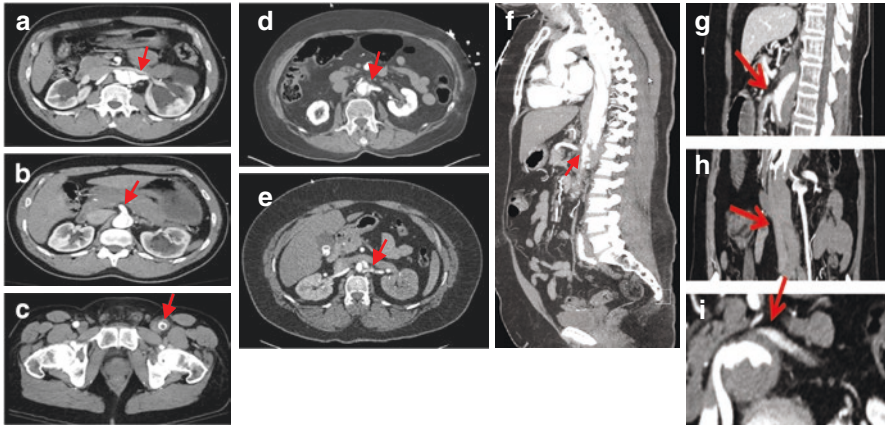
Representative computed tomography images demonstrating malperfusion in type A aortic dissection patients. First panel top (a) Axial view with right renal artery supplied by the true lumen and left renal artery (red arrow) supplied by the false lumen (Previously published in Lawton et al., The profound impact of combined severe acidosis and malperfusion on operative mortality in the surgical treatment of type A aortic dissection. *J Thorac Cardiovasc Surg* 2018;155:897–904.). First panel middle (b) Axial view with superior mesenteric artery (red arrow) supplied by the false lumen (Previously published in Lawton et al., The profound impact of combined severe acidosis and malperfusion on operative mortality in the surgical treatment of type A aortic dissection. *J Thorac Cardiovasc Surg* 2018;155:897–904.). First panel bottom (c) Axial view with malperfusion of the left femoral artery (red arrow). (Previously published in Lawton et al., The profound impact of combined severe acidosis and malperfusion on operative mortality in the surgical treatment of type A aortic dissection. *J Thorac Cardiovasc Surg* 2018;155:897–904.). Second panel top (d) Axial view with malperfusion of the left renal artery (red arrow). Second panel bottom (e) Axial view with malperfusion of the left renal artery (red arrow) with multiple areas of intimal flap noted. Third panel (f) Sagittal view with extensive disease of the dissected thoracic and abdominal aorta and malperfusion of the celiac artery (red arrow). Fourth panel (g) Magnified sagittal view with malperfusion of the superior mesenteric artery (red arrow) due to intramural hematoma. (Previously published in Ong, C, Lawton JS, et al., The strongest risk factor for operative mortality in Acute Type A aortic dissection is acidosis: validation of risk model. *Seminars in thoracic and Cardiovascular Surgery* <https://doi.org/10.1053/j.semtcvs.2020.02.023>). Fourth panel (h) Magnified coronal view with malperfusion of the abdominal aorta due to intramural hematoma (red arrow). (Previously published in Ong, C, Lawton JS, et al., The strongest risk factor for operative mortality in Acute Type A aortic dissection is acidosis: validation of risk model. *Seminars in thoracic and Cardiovascular Surgery* <https://doi.org/10.1053/j.semtcvs.2020.02.023>). Fourth panel (i) Magnified axial view with malperfusion of the left renal artery (red arrow). (Previously published in Ong, C, Lawton JS, et al., The strongest risk factor for operative mortality in Acute Type A aortic dissection is acidosis: validation of risk model. *Seminars in thoracic and Cardiovascular Surgery* <https://doi.org/10.1053/j.semtcvs.2020.02.023>)
